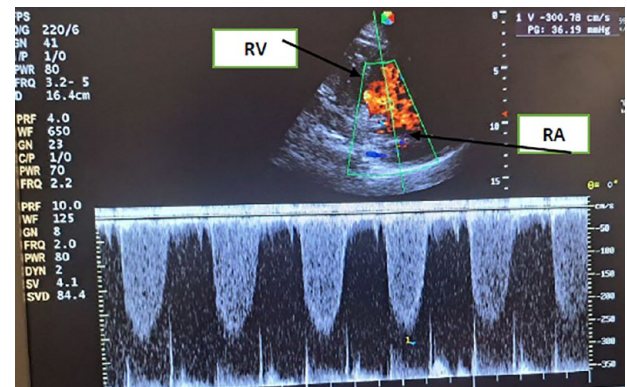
Parasternal long axis right ventricular inflow view showing tricuspid regurgitation with TV velocity 3 m/s, and right ventricular systolic pressure of 46 mmHg.
